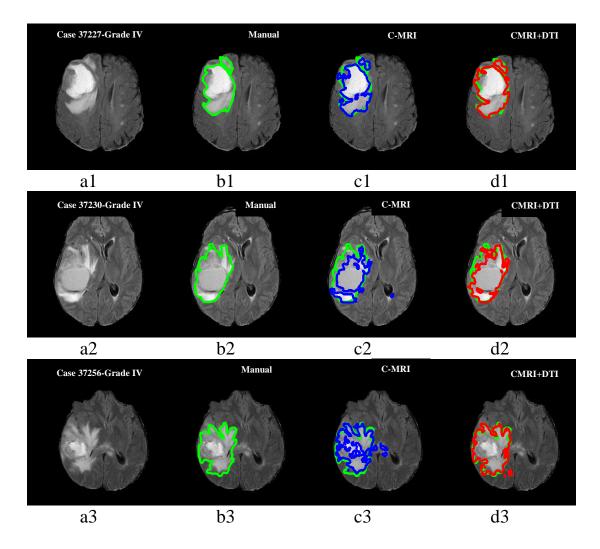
Comparison example of segmentation of complete tumours using C-MRI and C-MRI+DTI for three different cases with grade IV tumours. a1-a3) FLAIR image (a1: case 37227, a2: case 37230, and a3: case 37256), b1-b3) manual segmentation c1-c2) segmentation using C-MRI d1-d3) segmentation using C-MRI+DTI.
